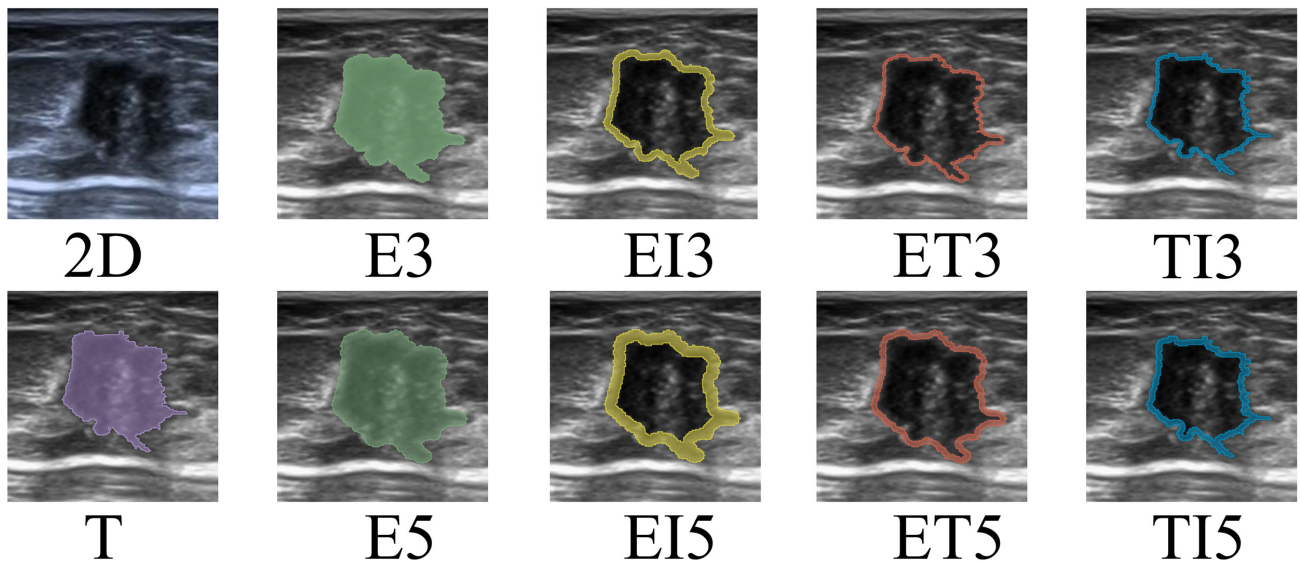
Examples of ROI delineation on the original 2D grayscale ultrasound images in 9 representative cases. T, tumor core ROI; E3, 3 pixels peritumoral ROI; E5, 5 pixels peritumoral ROI; EI3, 3 pixels transitional zone ROI; EI5, 5 pixels transitional zone ROI; ET3, 3 pixels outer peritumoral margin ROI; ET5, 5 pixels outer peritumoral margin ROI; TI3, 3 pixels inner margin ROI; TI5, 5 pixels inner margin ROI.
